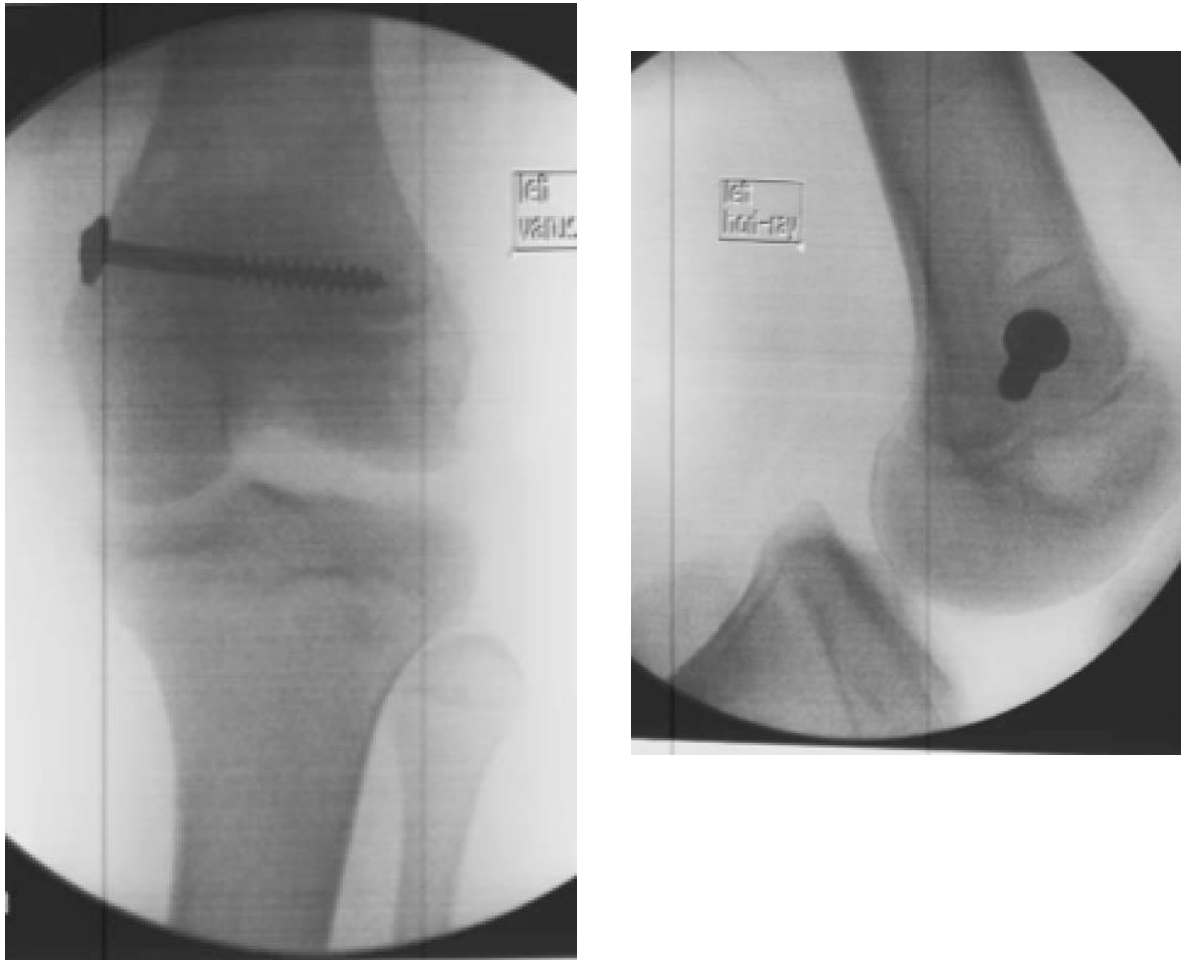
Case study. Plain radiographs at 6 weeks show the fracture internally fixed with a single metaphyseal screw, with maintained reduction and no signs of growth deformity following removal of the K wires.
